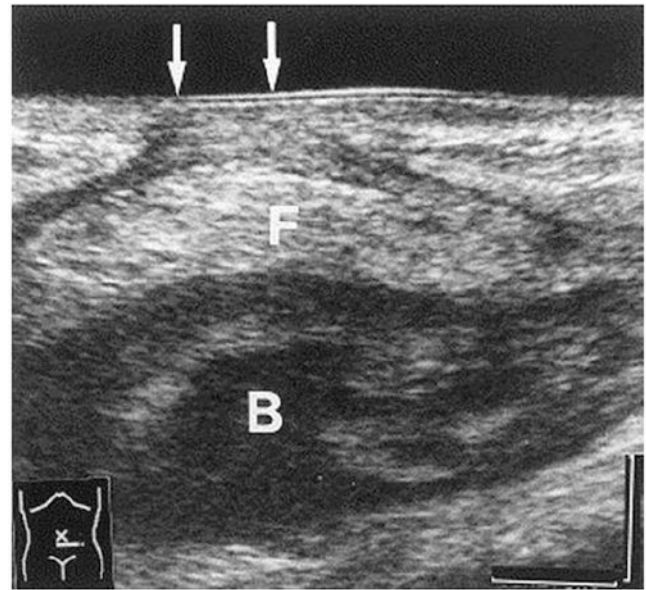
Sonogram of an abdominal wall hernia in a postoperative patient. Transverse scanning of the lower abdomen identified a fascial defect (arrow), herniated bowel loop (B), and omental fat (F) along the linea alba. (Reprinted with permission of Elsevier from Ishida et al.)
